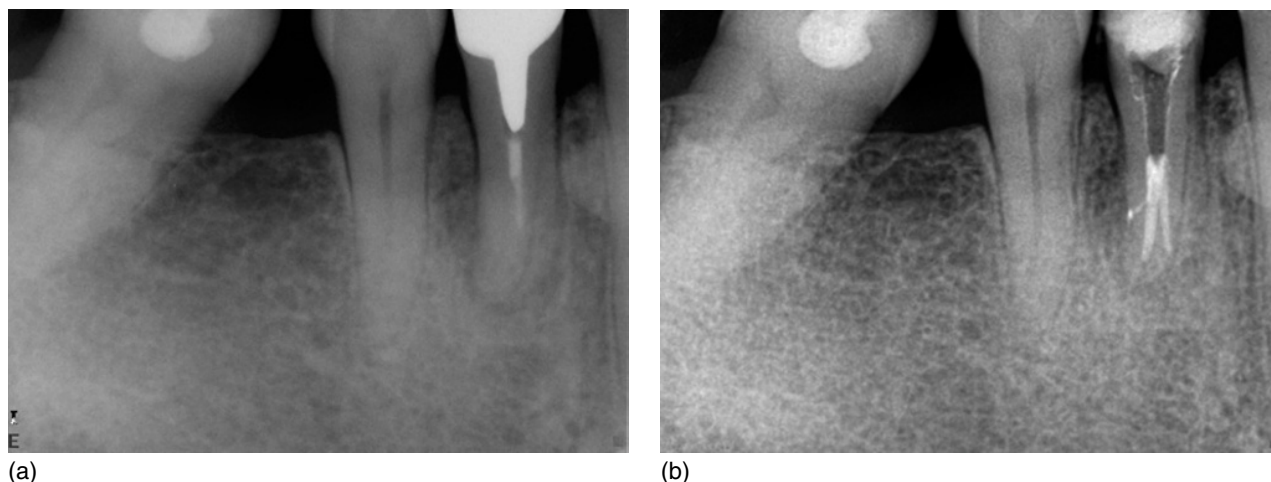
(a) Preoperative radiograph of a root canal treated mandibular premolar. The image of a second root suggests the presence of a second canal. (b) Final radiograph following re-root canal treatment showing the obturation of the second canal.
